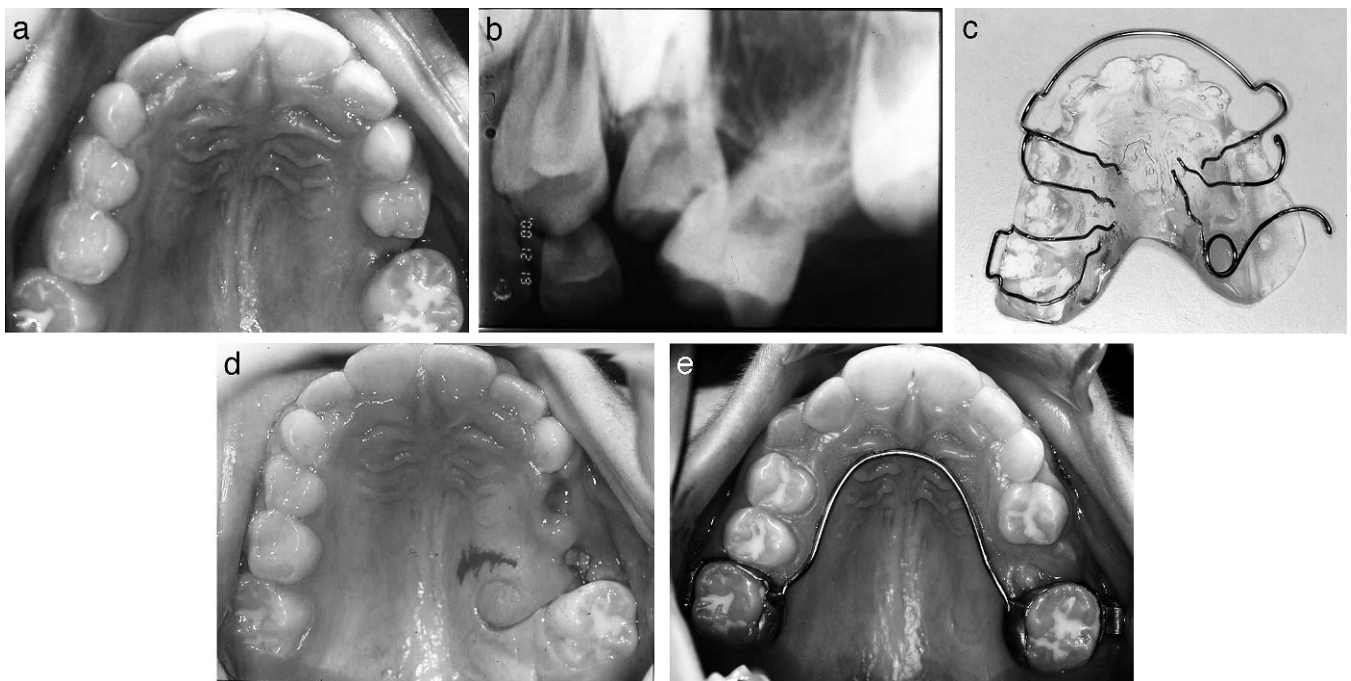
(a) Occlusal clinical view of a female patient, age 8 years, with deep submersion of the maxillary left deciduous second molar. (b) Periapical radiographic film showing severe tilting of adjacent teeth and impaction of the maxillary left second premolar. (c) Removable appliance used for opening space by distalization of the maxillary left first molar. (d) Occlusal clinical view after distalization. (e) Occlusal clinical view 2.5 years after surgical extraction of the maxillary left deciduous second molar and space maintenance with a palatal arch. The permanent successor erupted spontaneously in the dental arch. The patient was treated by one of the authors (SC). Reproduced with permission from *Treatment of Impacted Teeth* (by Becker A; Oxford: Wiley Blackwell Publishers; 2012).
